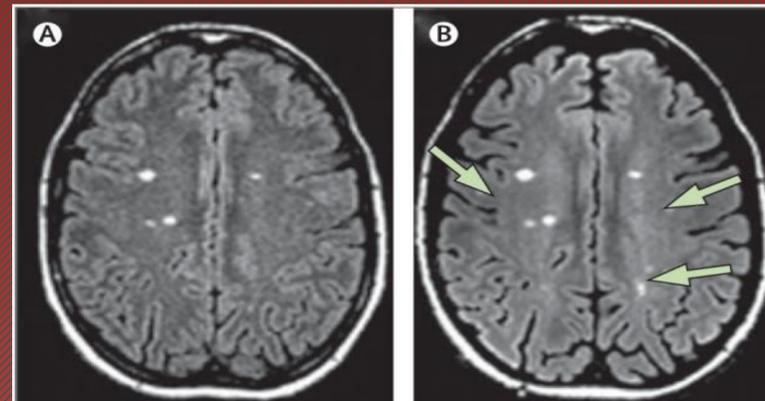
Axial FLAIR images from a 48 year-old woman with SPMS on a 1.5 tesla scanner (A) vs. a 3.0 tesla scanner (B).<sup>8</sup>
